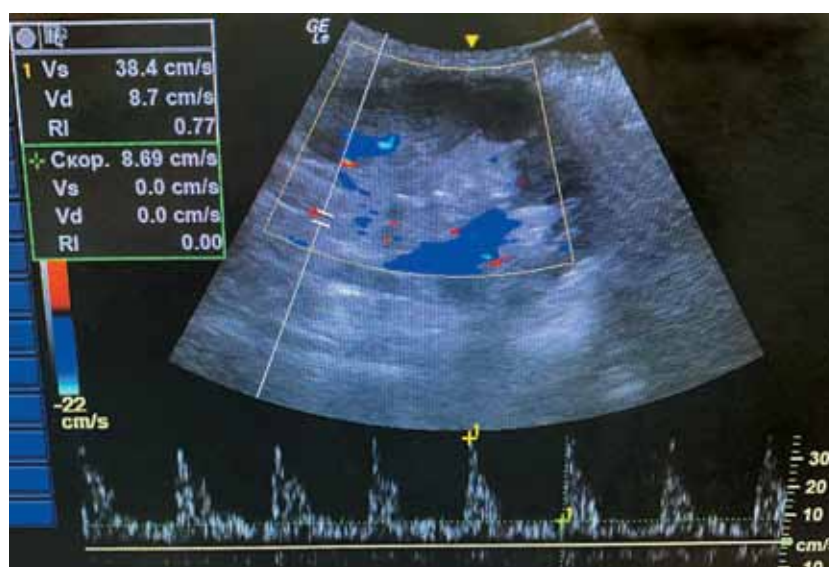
Intraoperative kidney graft ultrasound
